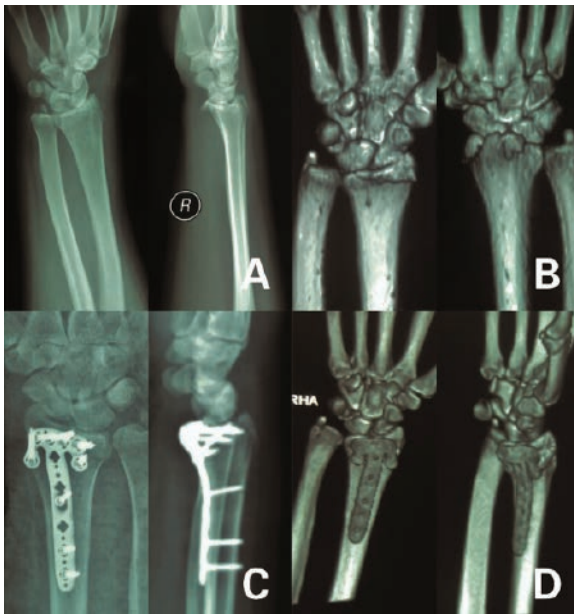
Radiograph obtained pre-operatively and two days postoperatively in a 49-year-old woman who had undergone ORIF using a VA-LCP. (A) Pre-operative images demonstrate an intra-articular distal volar marginal rim fracture with extension into the dorsal surface; (B) Postoperative images after ORIF with VA-LCP.
